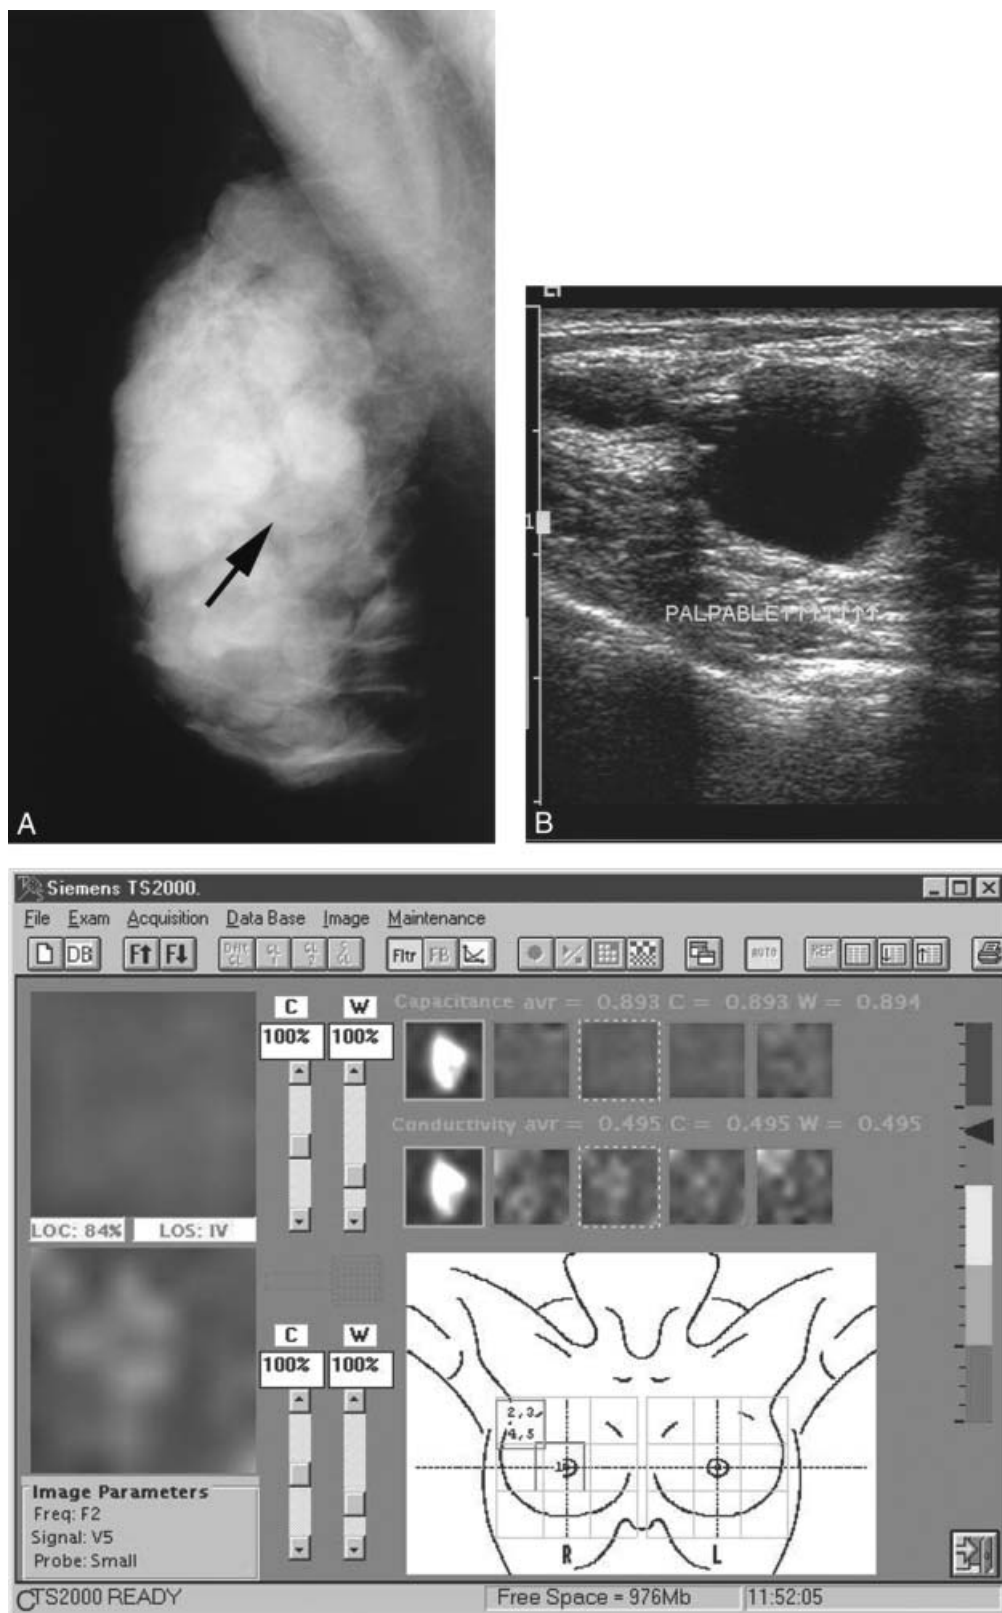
A 46-year-old woman referred to mammography due to a suspicious palpable lump in her right breast. A. Mammography showed several circumscribed lesions (arrow) which were classified as probably benign. B. Ultrasonography showed an anechoic lesion with pronounced acoustic enhancement at the location of the palpable lump, and described as a simple cyst. C. This image represents a false-positive case. TransScan showed marked inhomogeneity in conductivity maps; the finding was classified as suspicious for malignancy by the LOS algorithm.
